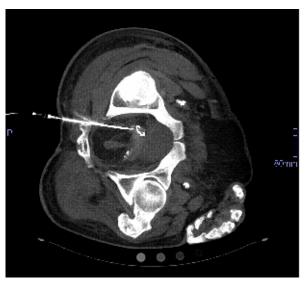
A 17 mm maximum intensity projection of a CT-Scan shows a guide-wire coiled within the lumen of the right seminal vesicle and an angiographic catheter sheath inserted into the seminal vesicle.
